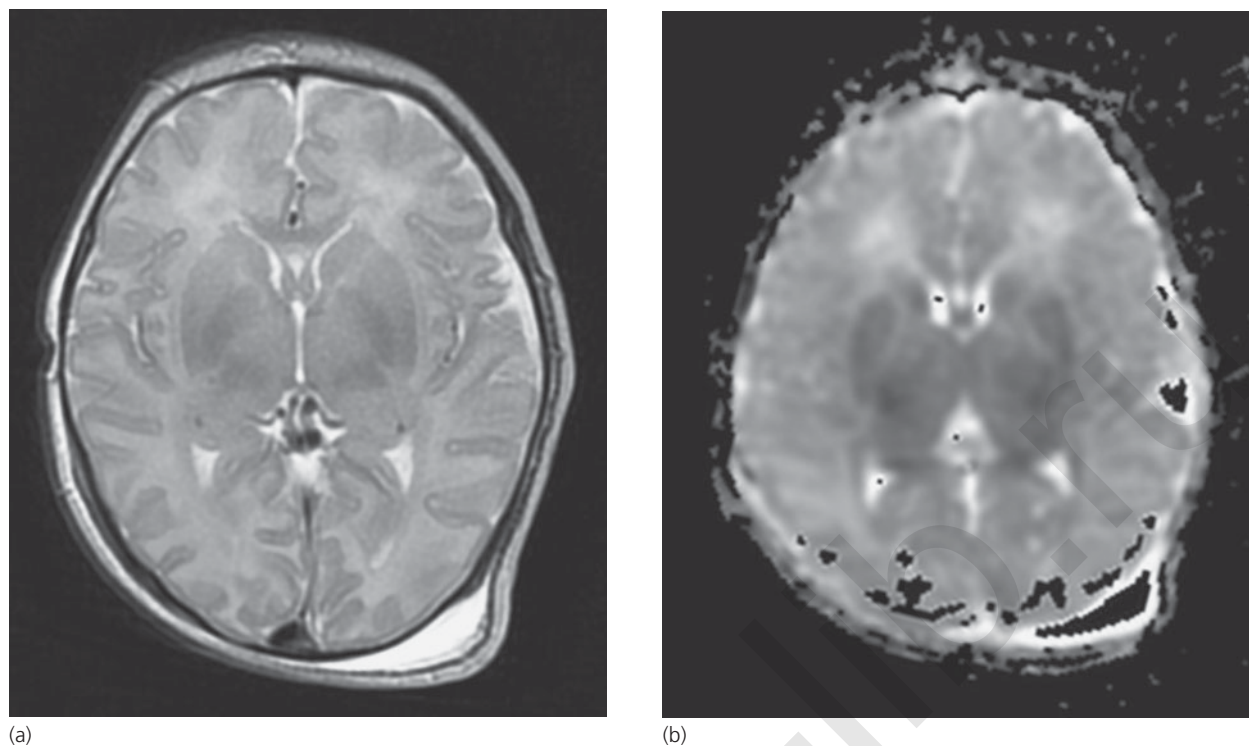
(a,b) Magnetic resonance imaging hypoxic-ischemic brain injury. (a) Axial T2 and (b) adjusted diffusion coefficient (ADC) map from the diffusion-weighted imaging (DWI). Signal abnormality in the newborn is often subtle on T1 and T2 imaging, and is influenced by gestation. DWI, when performed within an appropriate timeframe, is helpful in determining the extent of abnormality. In this term infant, extensive restricted diffusion is clearly evident within the basal ganglia (low signal on the ADC) in keeping with a profound hypoxic ischemic event.
